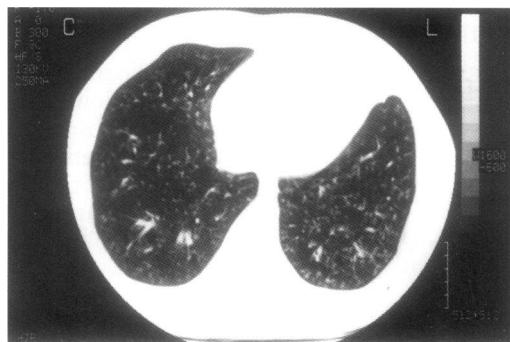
Thoracic computed tomographic scan showing small rounded or Y-shaped opacities located near the ends of the bronchovascular branches separated from the adjacent pleura by 2–3 mm.
